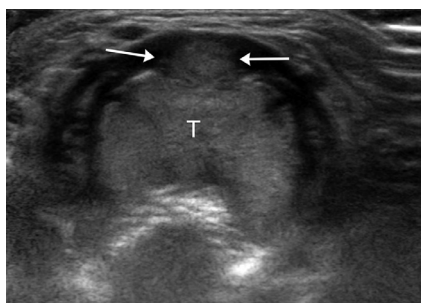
Ectopic thyroid. 22-day-old girl with abnormal congenital blood spot screening. Transverse gray scale ultrasound image at the floor of the mouth shows the thyroid gland as a solid nodule (between arrows), isoechoic to the tongue (T).
